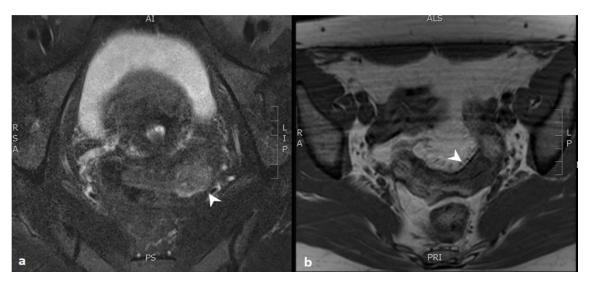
41-year-old-woman undergoing evaluation of pelvic pain and vaginal bleeding. a Axial T2 MR image with fat saturation demonstrates a mildly hyperintense endoluminal sigmoid colon mass (arrowhead). b Axial T1 MR image demonstrates an intermediate intensity mass at the same location (arrowhead). This mass was later proven to be a sigmoid colon adenocarcinoma.
